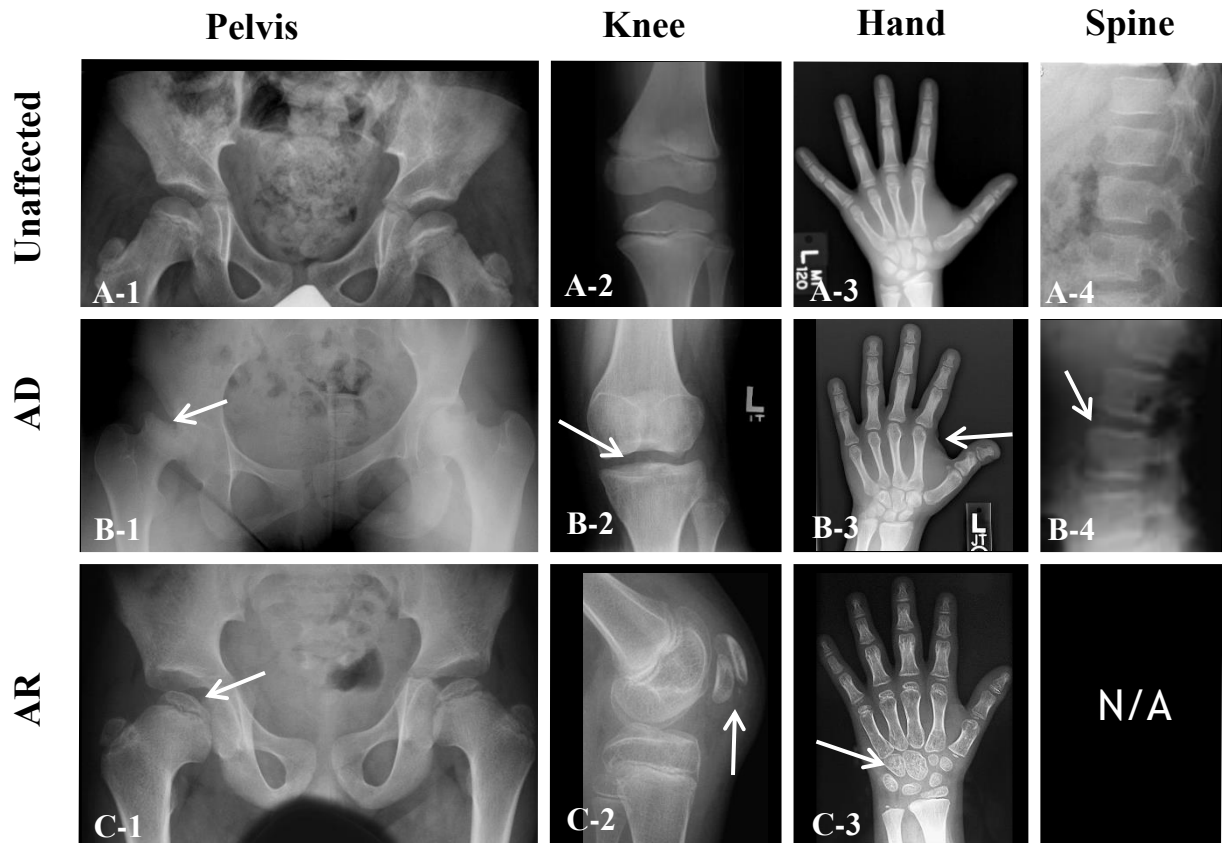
Radiographic Phenotype of Autosomal Dominant and Autosomal Recessive MED. A) Unaffected Adolescent films from an unaffected individual. A-1) AP Pelvis at age 9. A-2) AP knee (Figure for A-2 is is modified from Boeyer and Ousley 2016 [104]). A-3) Hand at age 12. A-4) Lateral spine at age 12. B) Autosomal dominant MED due to *COMP* mutations. B-1) Female pelvis at age 15 with flattened, irregularly shaped capital femoral epiphyses. B-2) Female knee at age 15 with flattened knee epiphyses. B-3) Female hand at age 15 with brachydactyly. B-4) Male spine at age 13 with irregularly shaped vertebral bodies and platyspondyly. C) Autosomal recessive MED due to mutations in *SLC26A2* (Figures for C are modified from Unger et al. 2008[59]). C-1) Pelvis with irregularly shaped capital femoral epiphyses. C-2) Knee depicting clinically distinctive double-layered patella. C-3) Advanced carpal ossification of the carpals.
